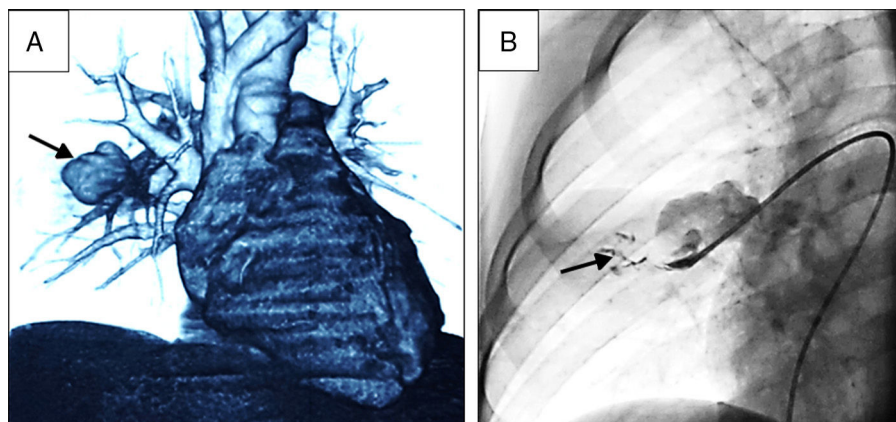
(A) Initial CT scan. 3D reconstruction showing the pulmonary artery pseudoaneurysm (arrow) in the right interlobar artery of 25×22 mm with short neck and ostium of 7.8 mm in diameter. (B) Initial Angiography. Extravasation of contrast of the eroded pulmonary artery pseudoaneurysm to pulmonary parenchyma (arrow).
